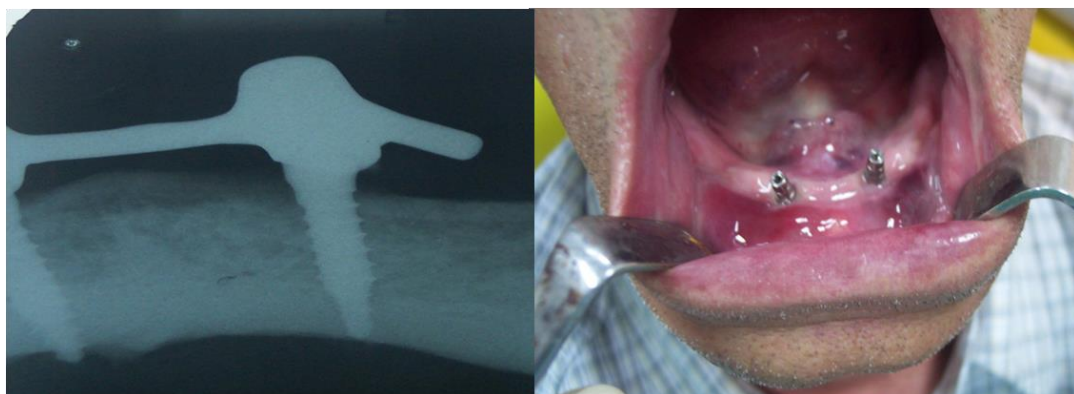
Inserted two MDIs in anterior mandible (X-ray and clinical image)
